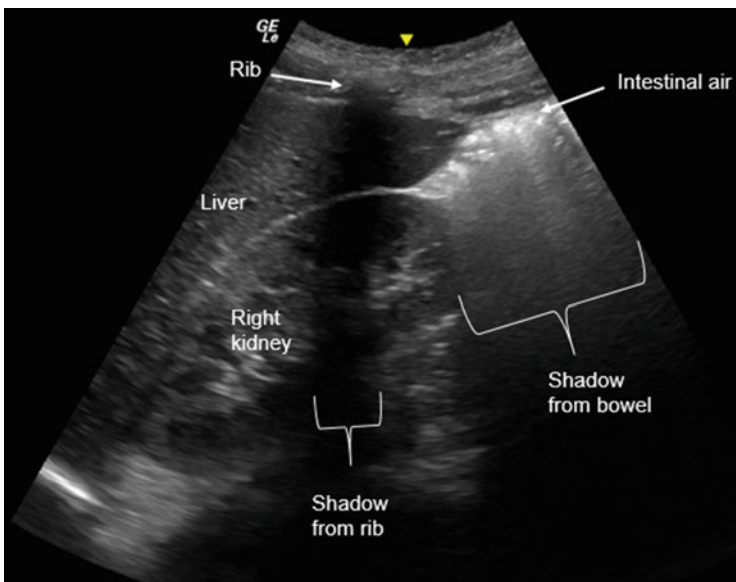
Ultrasound image showing shadowing from intestinal air. This is a longitudinal view through the liver and right kidney. Intestinal air is seen as the hyperechoic (bright) areas near the tip of the liver on the right side of the screen. Note that “dirty” shadows extend deep to the air in the intestine and obscure detail of deeper structures including part of the lower pole of the right kidney. They are referred to as “dirty” because they are brighter than “clean” shadows that arise from structures like ribs
